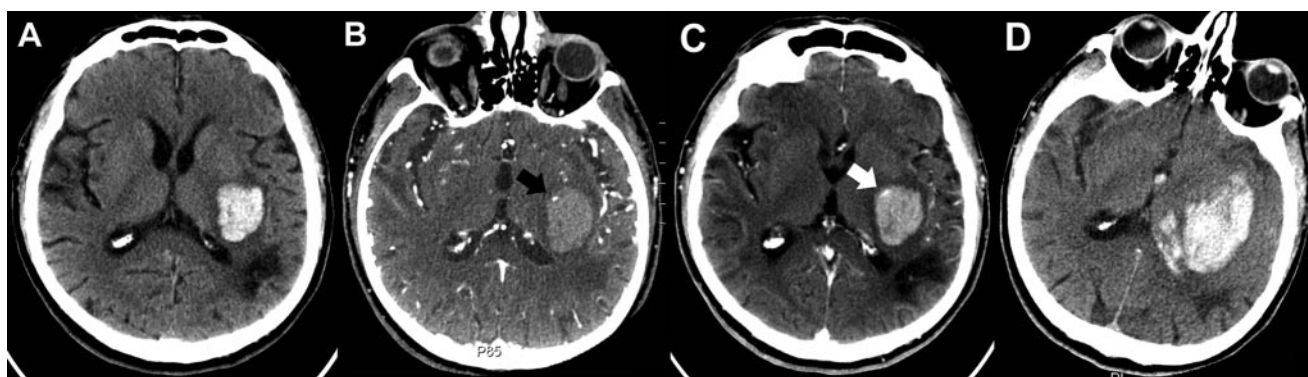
Patient with spot sign, demonstrating extravasation and hematoma expansion. CT slice selection has been optimized for hematoma configuration, not for head position. A, Unenhanced CT demonstrates left posterior putaminal and internal capsule hematoma with mild surrounding edema. An old parieto-occipital infarct is seen posterior to this. B, A small focus of enhancement is seen peripherally on CTA source images, consistent with the spot sign (black arrow). C, Postcontrast CT demonstrates enlargement of the spot sign, consistent with extravasation (white arrow). D, Unenhanced CT image 1 day after presentation reveals hematoma enlargement and intraventricular hemorrhage.
